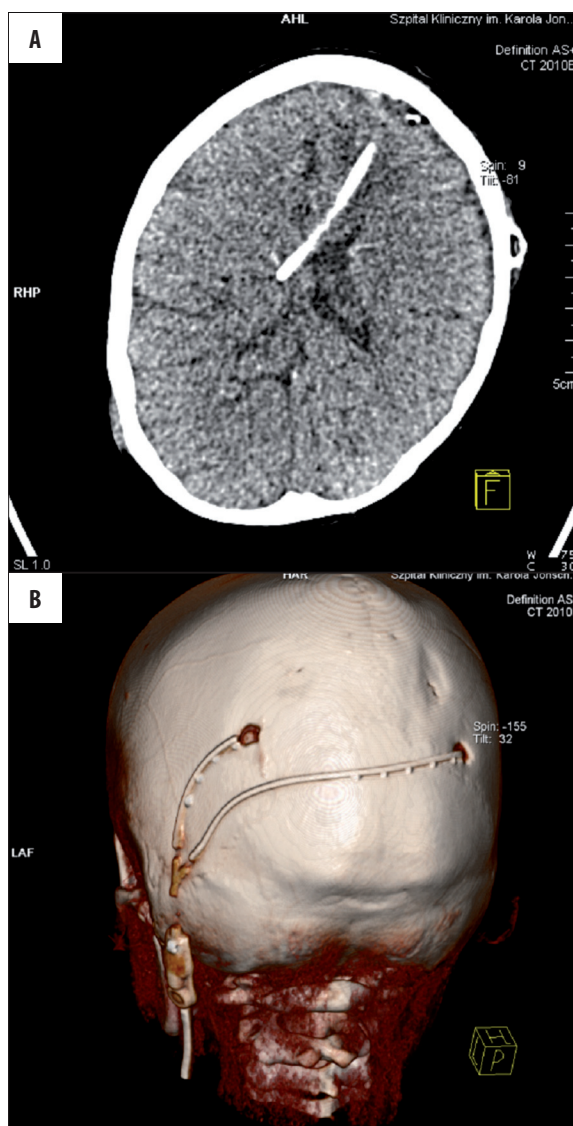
Nonenhanced computed tomography. (A) axial brain CT, position of the ventriculo – peritoneal shunt catheter, (B) course of the catheters outside the skull in VRT. Both images were obtained in the low-dose protocol.
